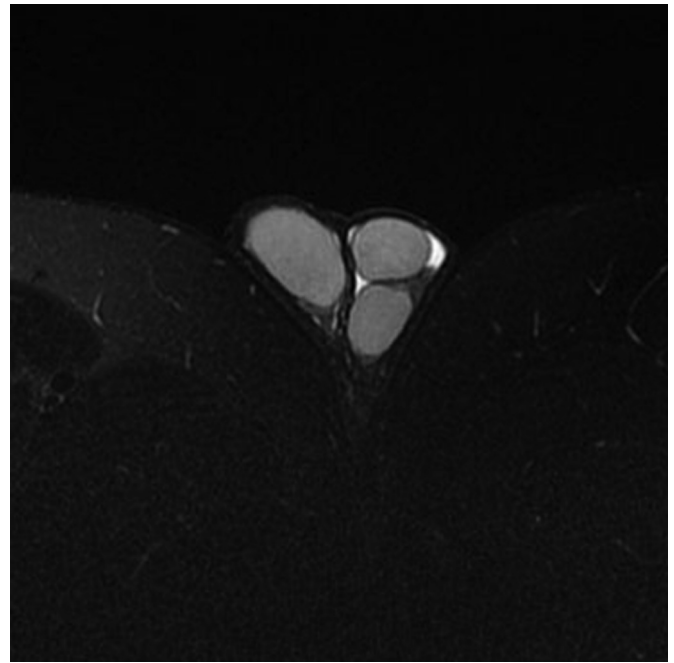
Axial MRI T2 FRFSE with fat saturation demonstrate three homogenous moderately high T2 signal intensity testicles inside the scrotal sac and confirm the diagnosis of triorchidism.
